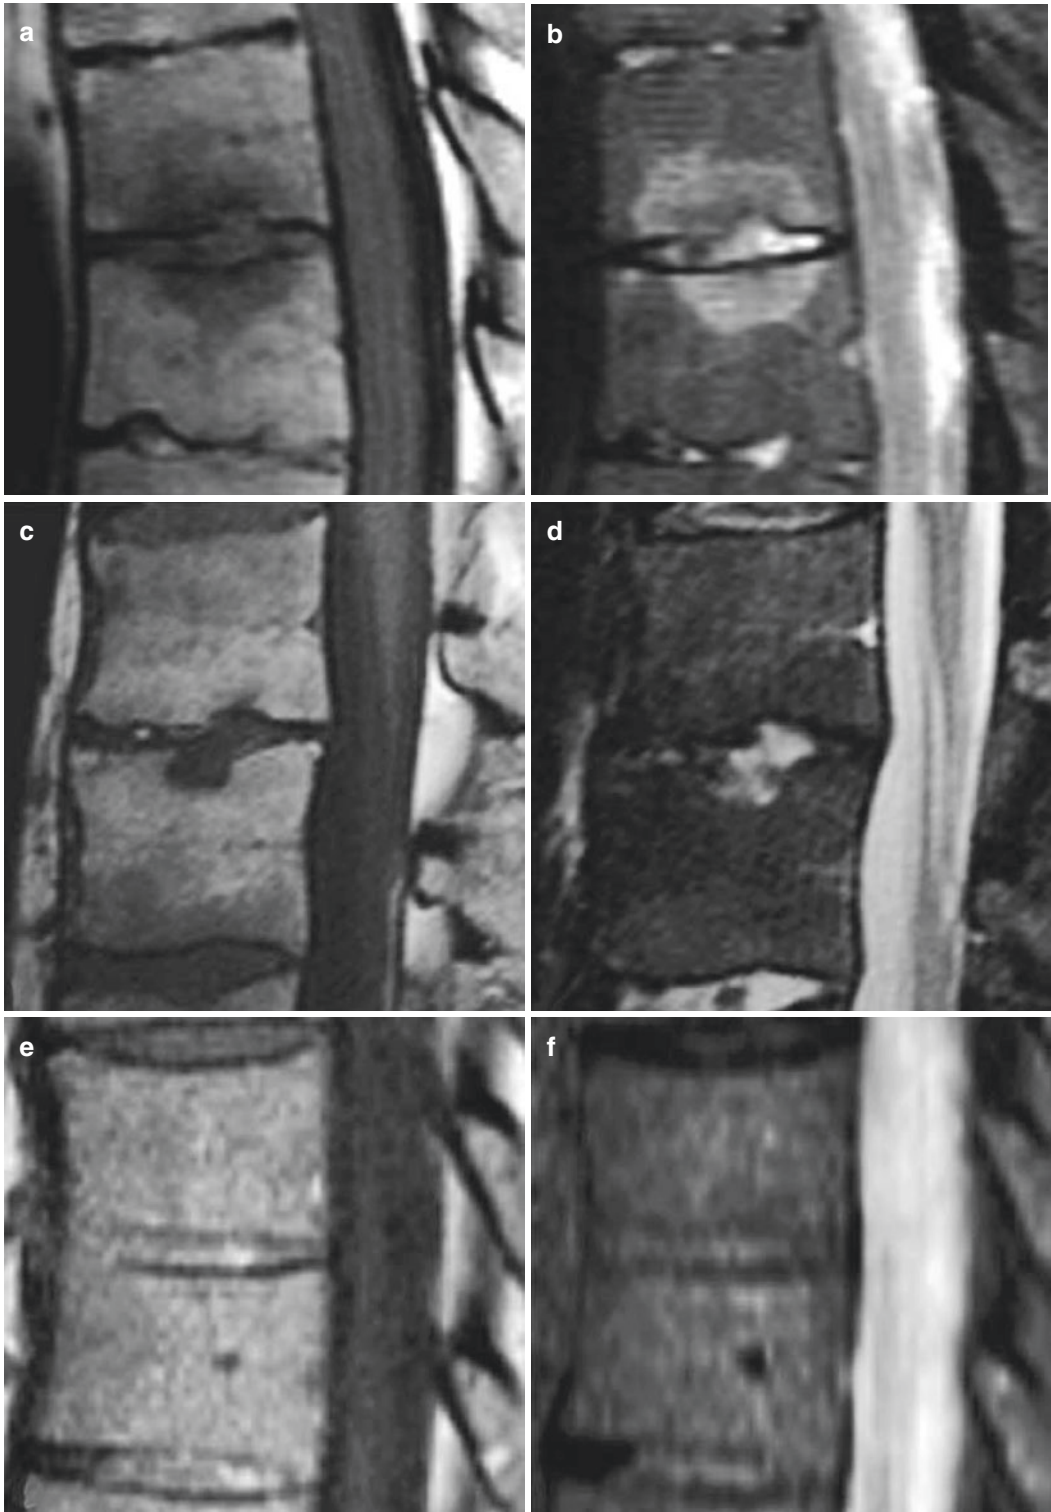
Classification of spinal changes in AS. (a) T1-weighted fast spin echo sequence (T1-FSE) and (b) short tau inversion recovery sequence (STIR) of acute Andersson lesion (class I lesion); (c) T1-FSE and (d) STIR
